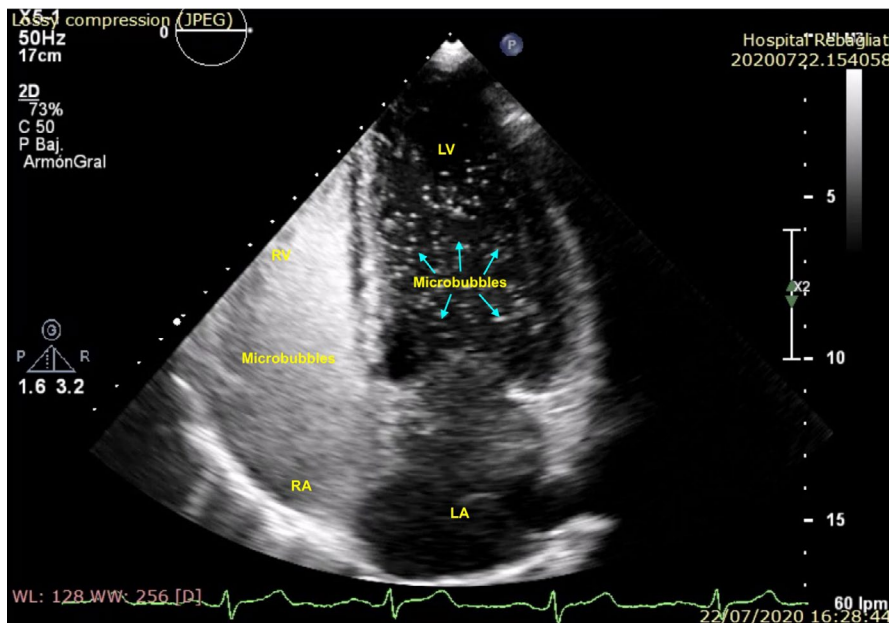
TTE, capture of apical four-chamber view at the fifth beat showing significant bubbles in left side. TTE: transthoracic echocardiography
